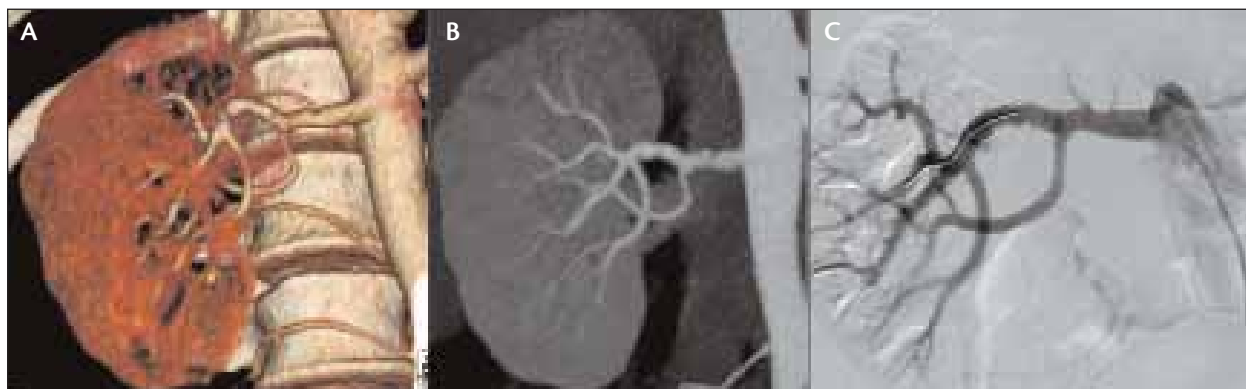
A 48-year-old woman with malignant hypertension diagnosed with FMD shown in three-dimensional CTA (A) and MPR (B) that was treated with angioplasty alone (C).
